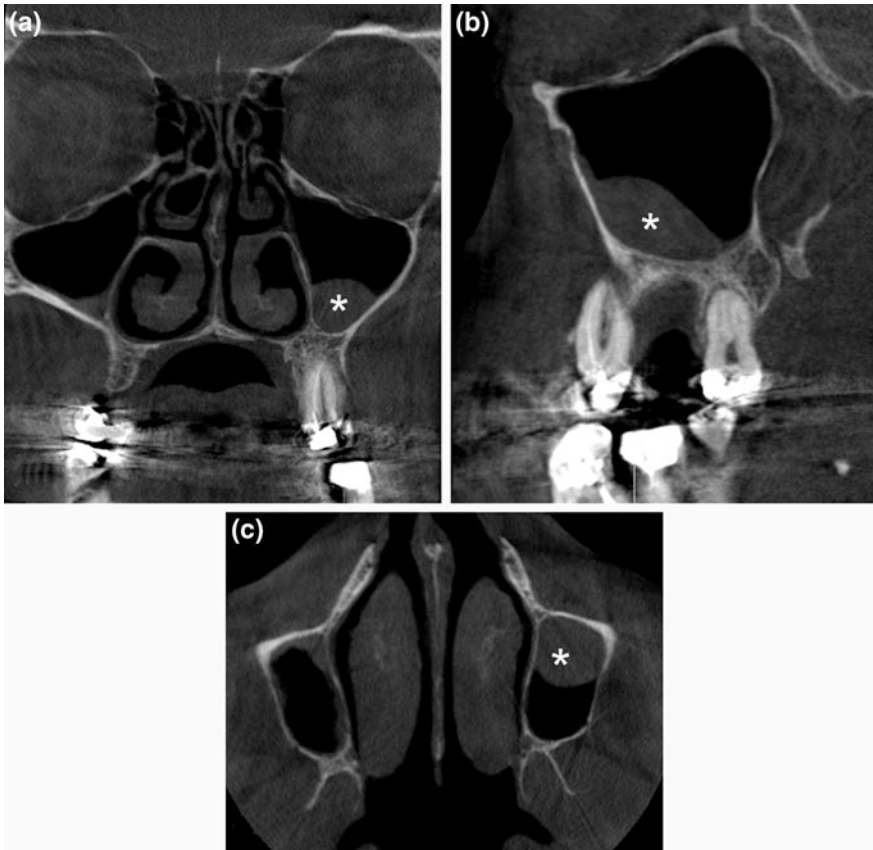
CBCT coronal (a), sagittal (b) and axial (c) sections demonstrating mucosal thickening (*) specially in the right maxillary sinus. Note the right and left draining channels (ostium) are opened
